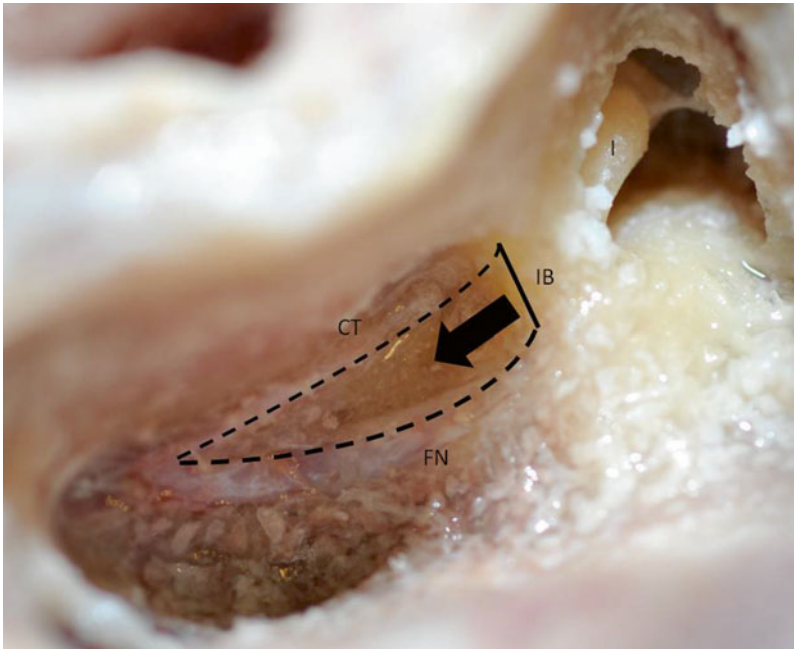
After the external auditory canal is thinned out, drilling is evenly advanced medially (*arrow*). The posterior tympanotomy is opened between the facial nerve and chorda tympani. The superior border is formed by a bony strut (incus buttress) which protects the incus (*FN* facial nerve, *CT* chorda tympani, *IB* incus buttress, *I* incus in fossa incudis)
